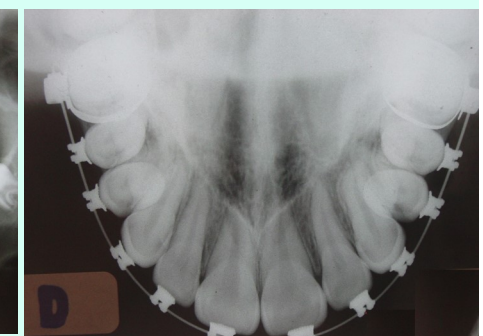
Radiographic evaluation (after 3 months): occlusal radiograph
